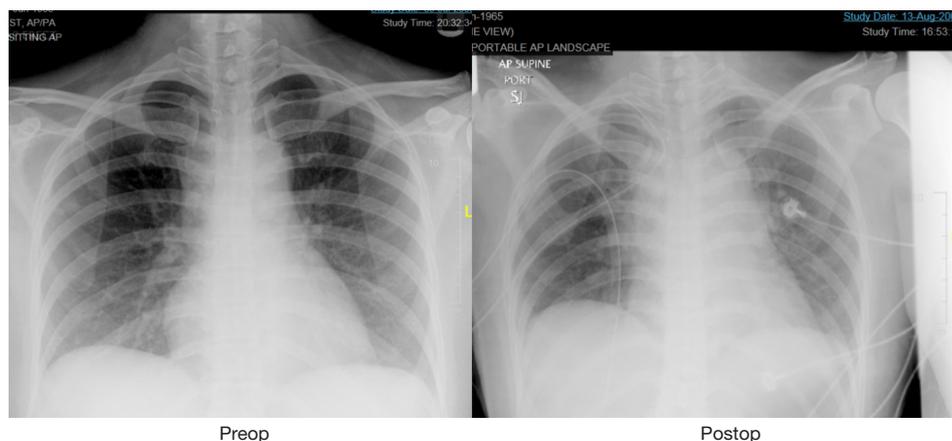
Chest radiograph of patient who underwent first UVATS lobectomy for lung cancer on August 13, 2009. UVATS, uniportal video-assisted thoracic surgery.
